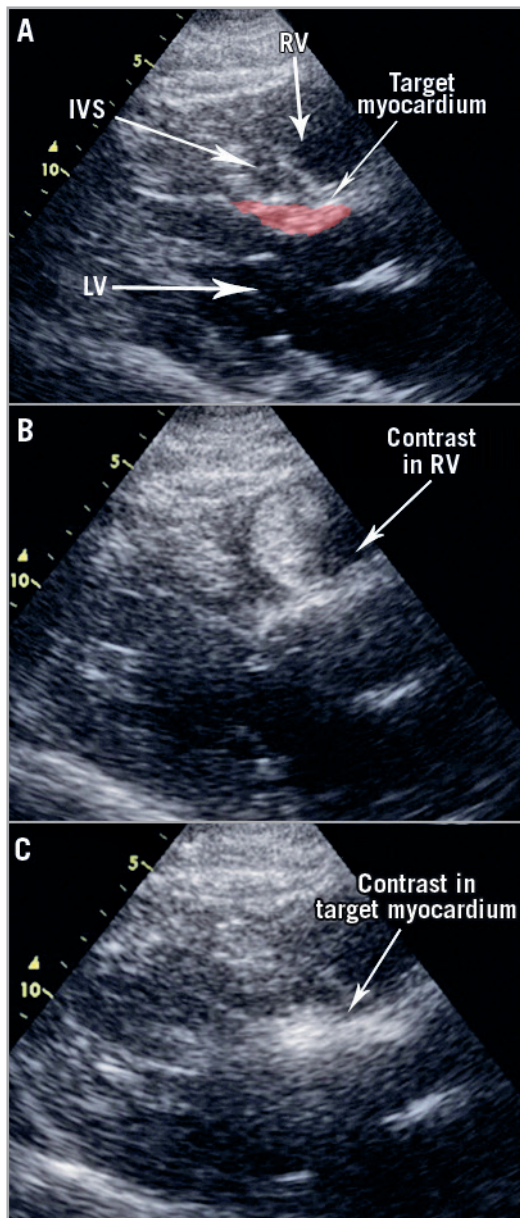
Myocardial contrast echocardiography studies. A) Parasternal long-axis echo view with relevant structures highlighted. Contrast injection into the common ostium of a septal; myocardial contrast is seen predominantly in the RV (B). There is some hyperenhancement in the target septum but this passes quickly (Moving image 2). C) Contrast localises to the target myocardium following occlusion of the chosen sub-branch.
